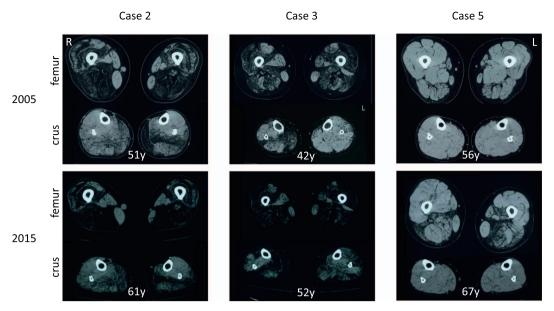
Ten-year follow-up CT of the lower extremities of female dystrophinopathy carriers. CT images of cases 2, 3 and 5, described in Supplemental Table 2, showed progressive muscle atrophy
